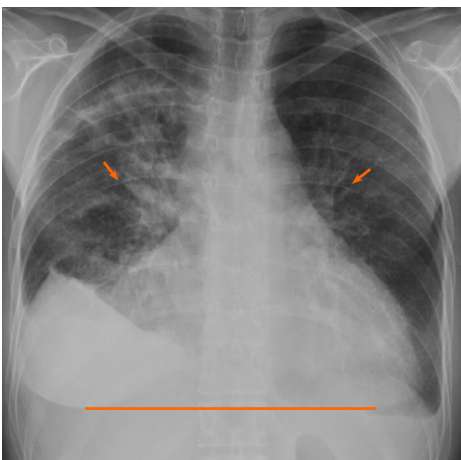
Chest radiograph revealed cardiomegaly (line) and bilateral opacities (arrows).
